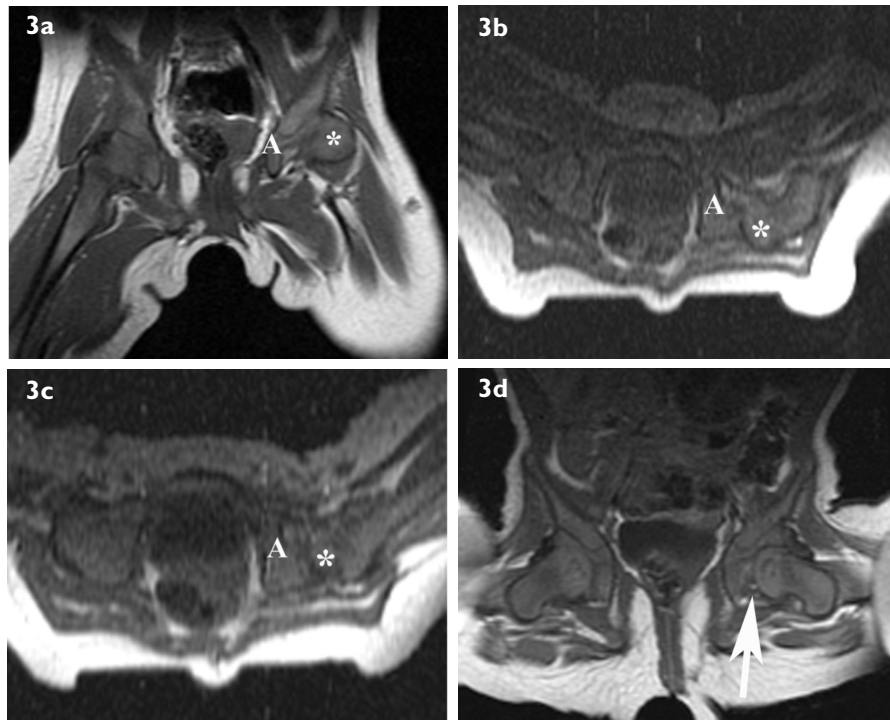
A nine-month-old infant diagnosed at the age of eight months with DDH on the left side. A three-week Pavlik harness treatment was unsatisfactory and closed reduction was performed within the open MR unit. (a) Coronal spin-echo T1-W MR image shows the posterosuperiorly dislocated left femoral head (*) and the shallow left acetabulum (A). (b & c) Axial fast spin-echo T1-W dynamic motion MR images performed during the Ortolani reduction manoeuvre show a repositioning of the proximal femoral epiphysis from posteriorly into the acetabular cup (A). Coverage of the proximal femoral epiphysis (*) is poor posteriorly and a tendency towards posterior subluxation is found. Adductor tenotomy was performed within the open MR imaging unit to allow for sufficient abduction and the tendency for subluxation was no longer present. Note the flattening of the buttocks resting on the horizontal plate of the plastic spica table within the MR imaging unit. (d) Coronal spin-echo T1-W MR image after closed reduction shows that the left proximal femoral epiphysis is now well-centred within the acetabulum, although a relatively large amount of fatty tissue remained interposed between the acetabulum and medial side of the femoral head consistent with pulvinar hypertrophy (arrow). At three-month follow-up, a new cast was applied, followed by bracing for one year. Six-year follow-up clinical examination was unremarkable and radiographical follow-up only demonstrated a slight irregularity of the left acetabulum.
